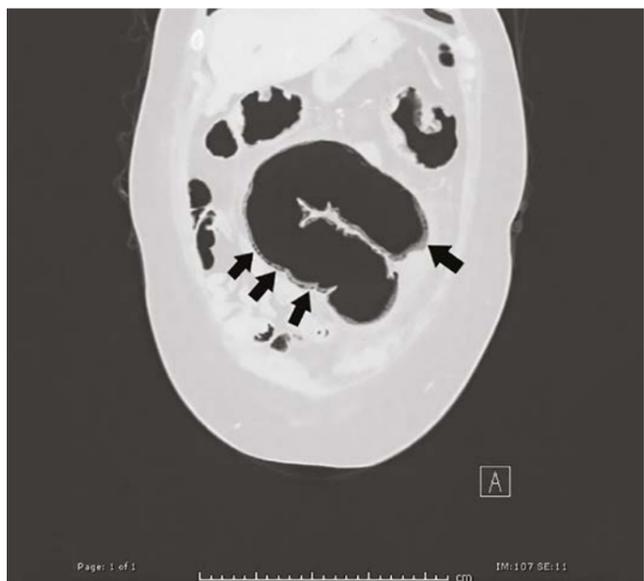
CT axial lung window. Further demonstration of the intramural gas within the large bowel.
